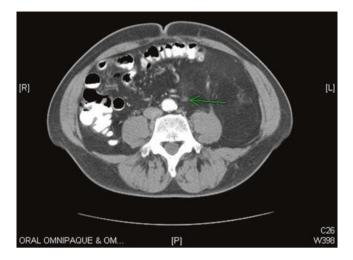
CT of low grade liposarcoma surrounding superior and inferior mesenteric vessels, green arrow shows encased mesenteric artery
